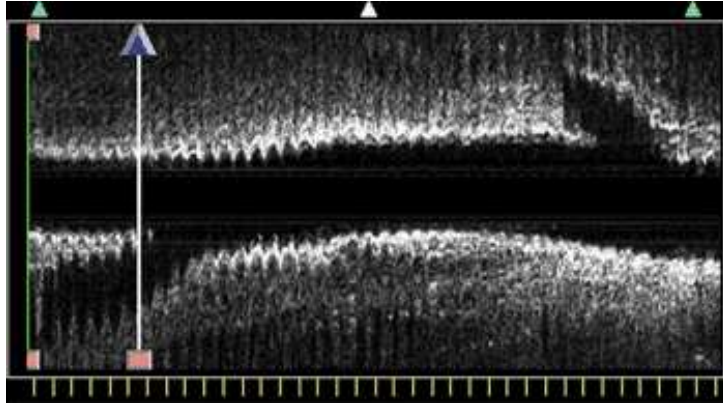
IVUS vessel reconstruction in JOMED's *In-Vision Gold Intravascular Ultrasound System*. [5].
